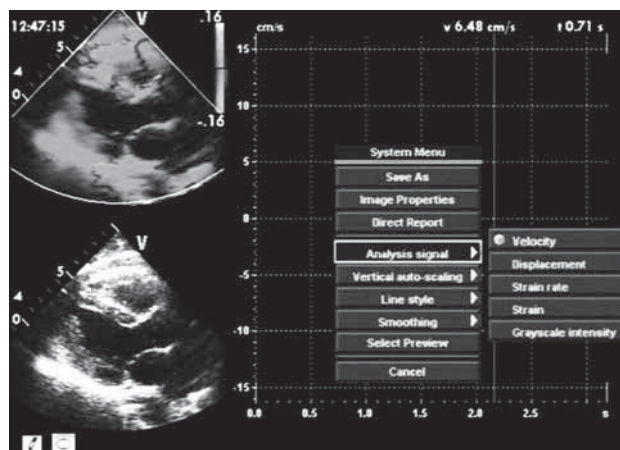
Regional myocardial motion, deformation parameters and grayscale intensity measured by the ultrasonic system (Vivid 7; General Electric Medical Systems), including velocity, displacement, strain rate, strain and grayscale intensity using tissue velocity imaging, tissue tracking, strain rate imaging and videodensitometric analysis.
